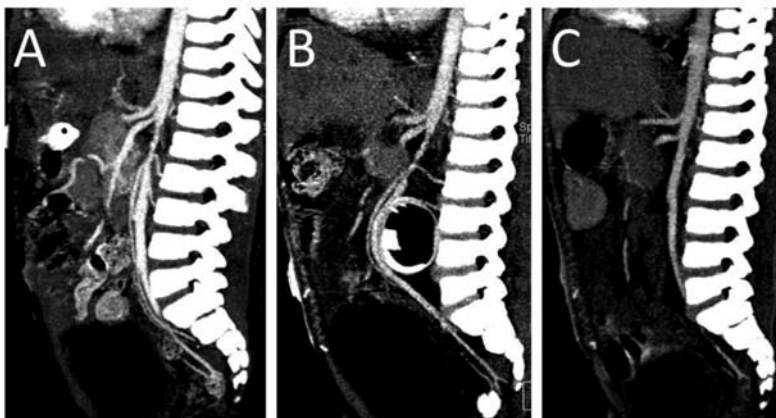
A) Preoperative CTA showing aortic stenosis
